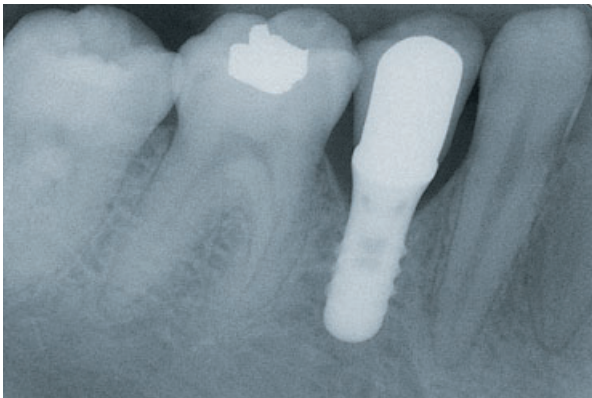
The related 2-year follow-up radiograph shows a so-called unfavorable relationship between the height of the suprastructure and the length of the supporting implant. The placement of a longer implant was not possible due to the limited local bone conditions.
